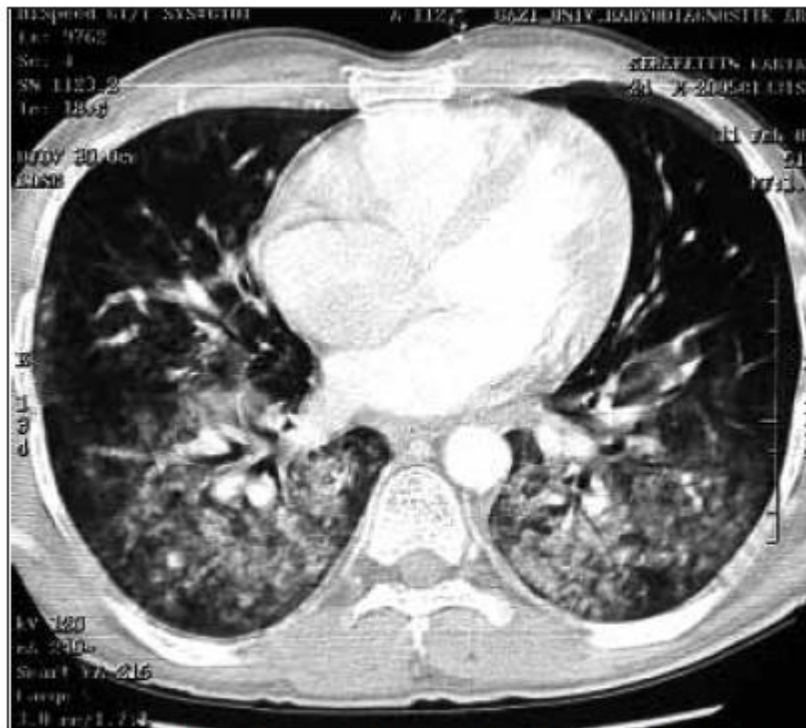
HRCT demonstrates bilateral alveolar infiltrates, predominantly in the lower zones
